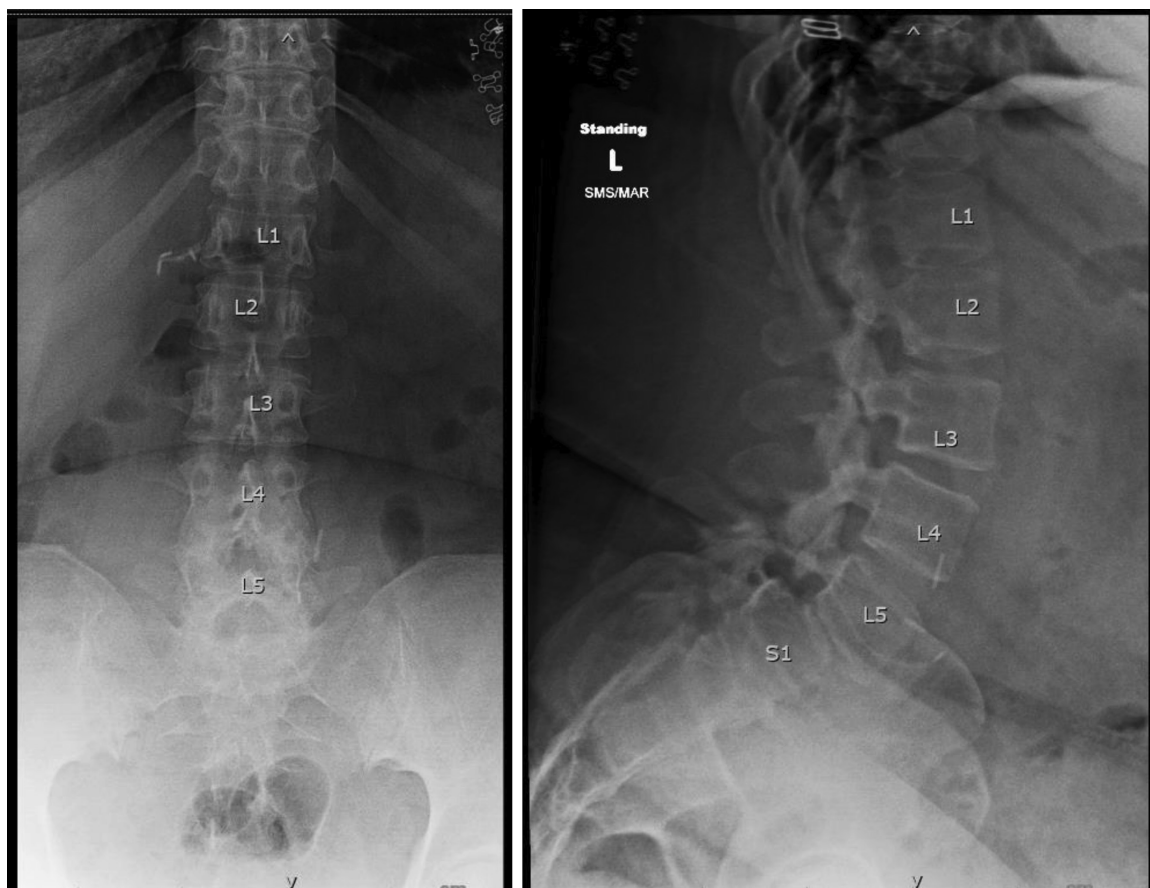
Anteroposterior and lateral radiographs of the lumbosacral spine—Note pars defect at L3 and L5. There is Grade 2 anterolisthesis of L5–S1 with loss of intervertebral height.
